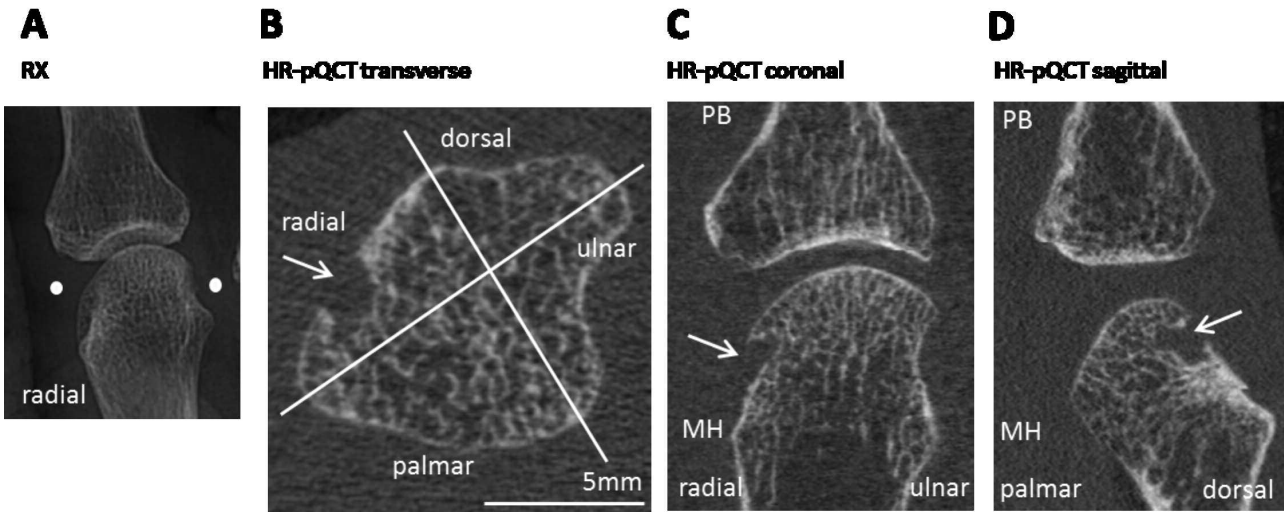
MCP joint on CR (A) and HR-pQCT imaging (B, C, D) of a 62-year-old patient with longstanding RA. The MCP joint is evaluated in transverse view in 4 quadrants (B) and simultaneously viewed in coronal (C) and sagittal (D) planes. A cortical break is seen in the radial quadrant, and in corresponding coronal and sagittal planes. White dots in A correspond to the location of the transverse slice in B. MCP: metacarpophalangeal; CR: conventional radiography; HR-pQCT: high-resolution peripheral quantitative computed tomography; PB: phalangeal base; MH: metacarpal head.
